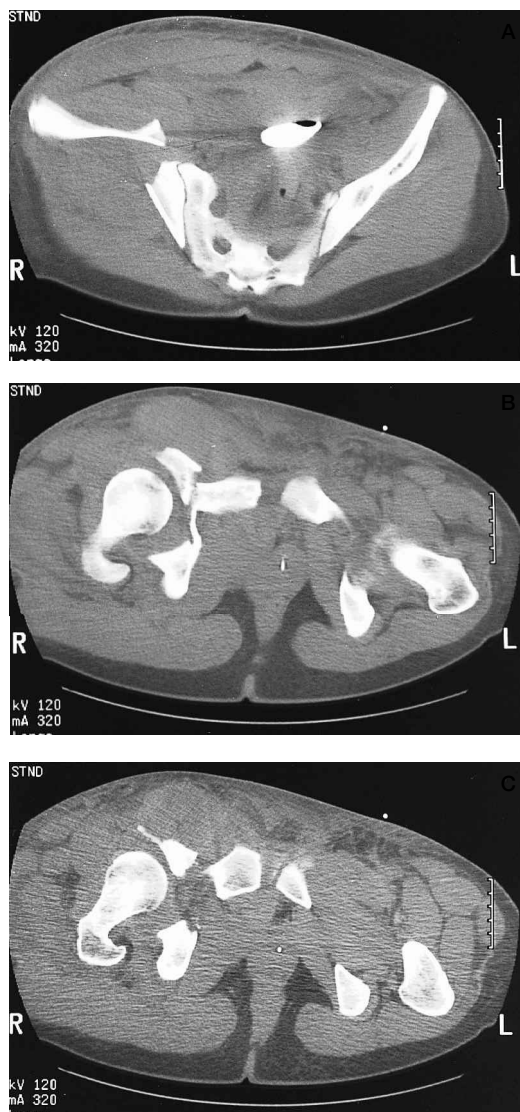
CT scans demonstrate external rotation of the anterior column (A) and anterior dislocation of the femoral head and an anterior wall fragment (B-C)
